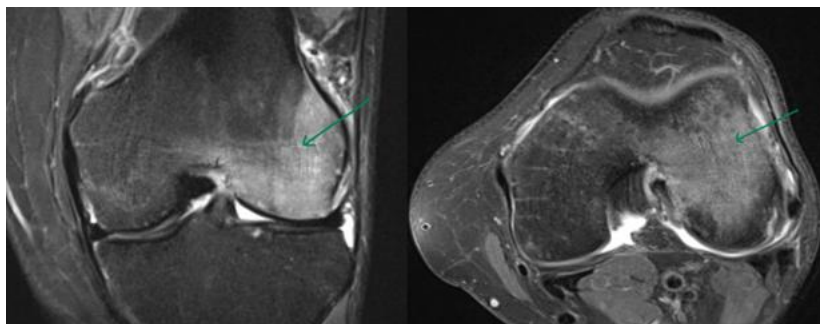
Left knee MRI; subchondral oedema of the lateral femoral condyle, more consistent with transient osteoporosis than an acute or subacute fracture.
